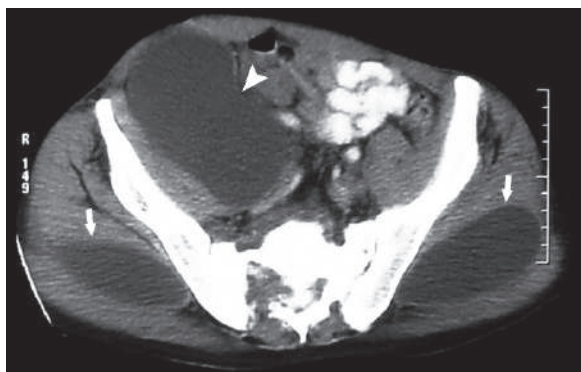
Axial pelvic CT in a patient with Pott's disease shows a large right psoas abscess (*arrowhead*), which drains into both gluteal muscles (*arrows*)
